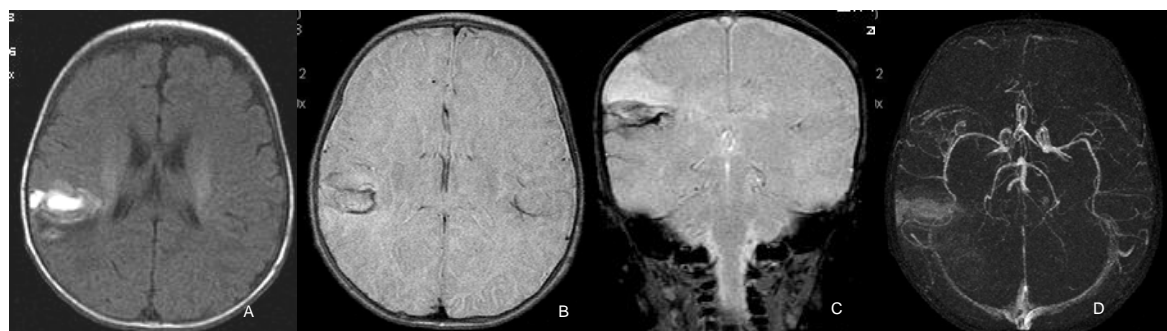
Axial FLAIR (A), GRE axial (B) and coronal (C). Of a 2-month-old boy, who presented with localized related epilepsy, showed subacute intraparenchymal hematoma at the right inferior parietal gyrus with dilated cortical veins and prominent posterior opercular branches of the right middle cerebral artery. Axial 2D PC MRA (D) showed no definite focal stenosis, aneurysm or A-V shunt. The hemorrhage could be from a small rupture, a cryptic AVM or cavernoma
